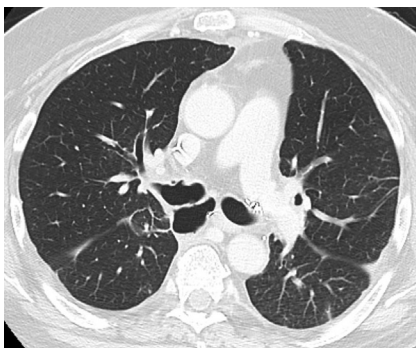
Computed tomography scan demonstrated dehiscence of the airway at the right side anastomosis, with air ingress into the mediastinum.
